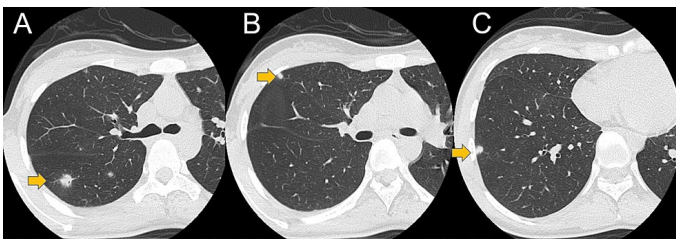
Chest CT image A, B and C show images displaced from cranial to caudal, respectively. Arrows indicate multiple nodules with random distribution in the lung field, representing septic embolism.
